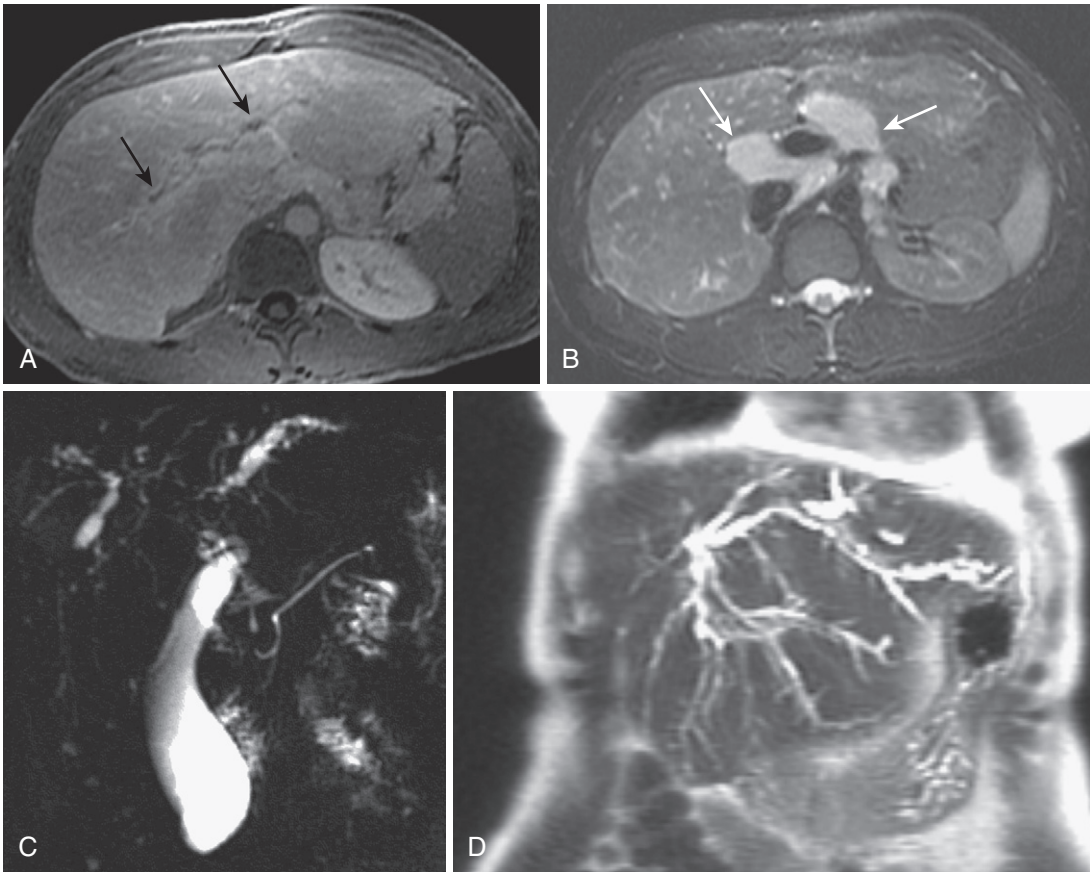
Primary sclerosing cholangitis (PSC). A, Delayed postcontrast image in a patient with mild, early PSC reveals periportal enhancement with irregular biliary ductal dilatation (*arrows*). B, The corresponding fat-suppressed T2-weighted image shows markedly enlarged reactive periportal lymph nodes (*arrows*). More extensive irregular, beaded ductal dilatation and stricturing is exemplified in patients with more advanced PSC on the MRCP (C) and coronal T2-weighted (D) images. Marked irregular ductal dilatation and stricturing peripherally with a characteristic central hypertrophy–peripheral atrophy pattern typifies end-stage PSC, as seen in this case on the heavily T2-weighted (E), fat-suppressed steady-state (F), and MRCP (G) images.
